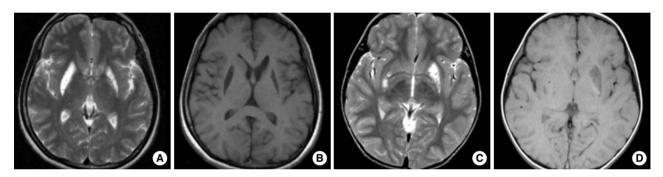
Brain MRI of the proband (A, B) and his nephew (C, D). (A) The T2 weighted image of the proband show bilateral striatal hyperintensities with necrosis. (B) The T1 weighted image of the proband show bilateral hypointensities with necrosis. (C) The T2 weighted image of his nephew shows bilateral putaminal hyperintensities without necrosis. (D) The T1 weighted image of his nephew shows bilateral putaminal hypointensities without necrosis.
